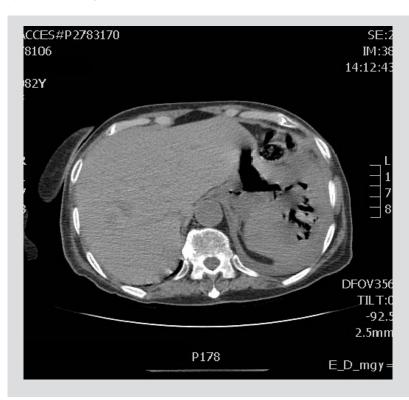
Abdominal CT shows a large necrotic splenic mass with air bubbles and a thin fistulous tract between the gastric lumen and the air-filled splenic necrotic cavity
